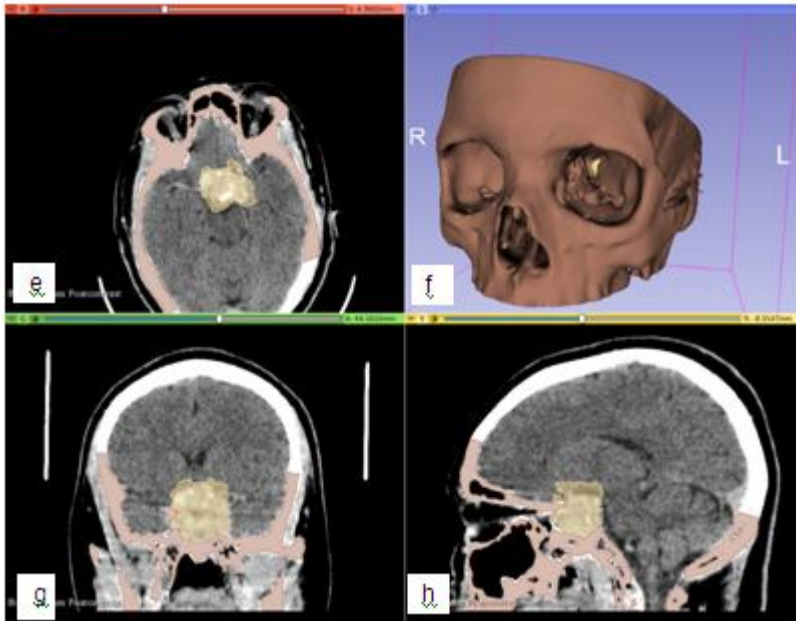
Case 1a-h. Lobulated mass in the pituitary fossa with 3D volume rendered images; the mass separately (a), pituitary fossa without the mass (b), mass in situ in the skull (c-d), facial bones (f), segmentation of mass on orthogonal CT stacks (e, g & h).
